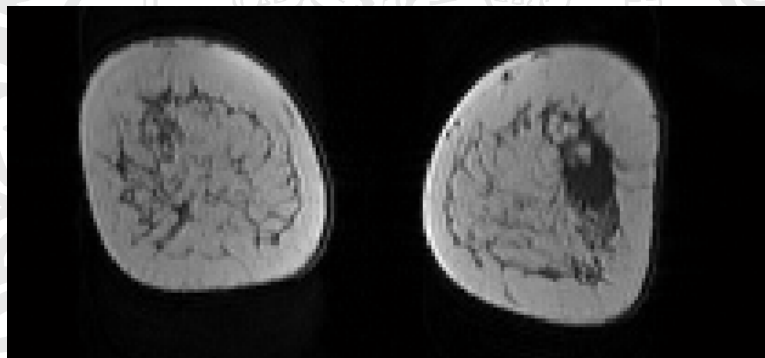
A slice of a DCE-MRI
